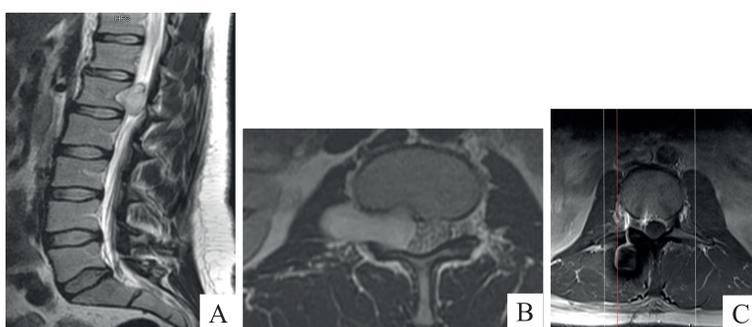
MRI (Plain) LS spine of patient 1 showed a neurogenic tumour at L2 level (A & B). It is of dumbbell shape, and belongs to Eden class 3 tumour. Post-operative MRI (plain) LS spine confirmed complete excision of the tumour (C).
